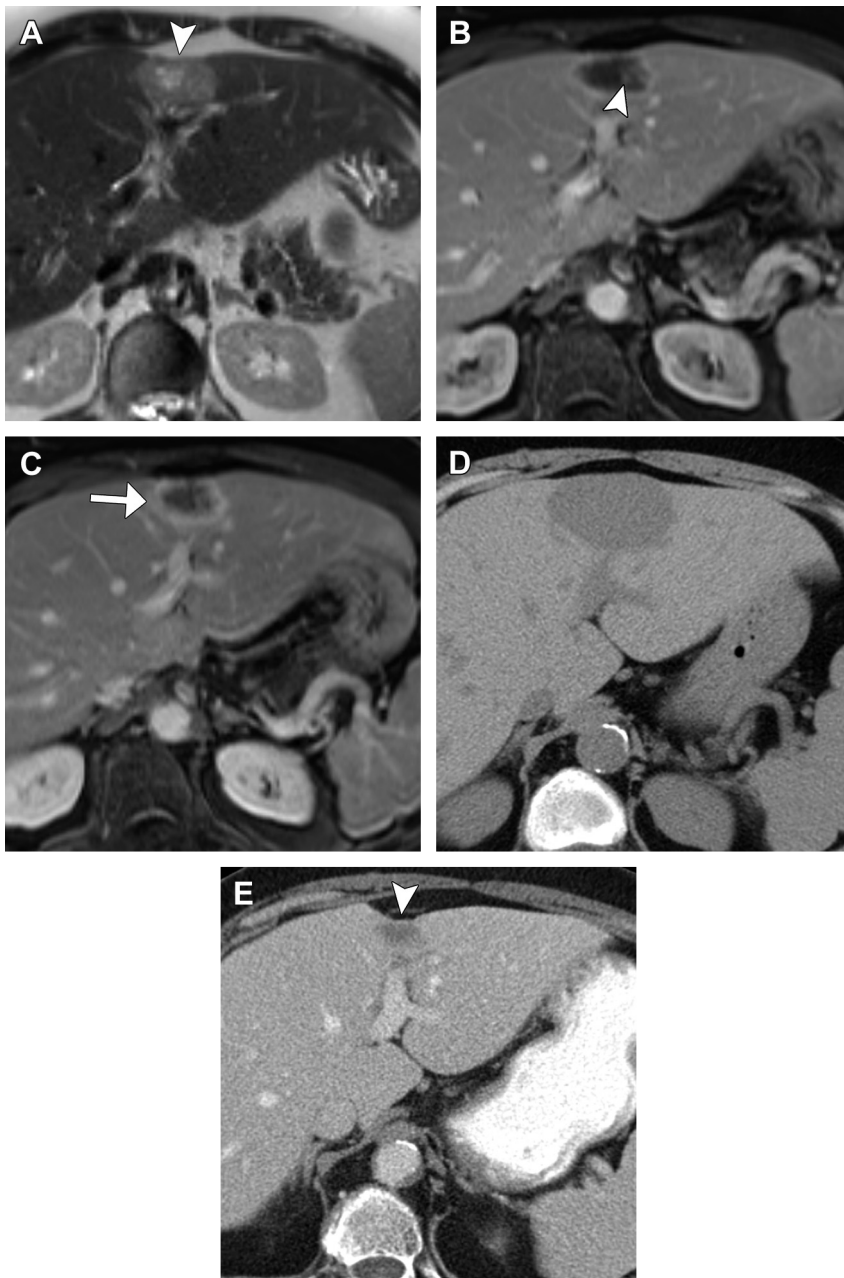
Sclerosing hemangioma (A) Heterogeneous, mildly T2 hyperintense mass with overlying capsular retraction (*arrowhead*). (B) Portal venous phase image demonstrates a continuous rim of enhancement with some internal nodular foci of enhancement (*arrowhead*). (C) Equilibrium phase image shows progressively thick rim of peripheral enhancement (*arrow*). Biopsy performed at this time was consistent with a hemangioma. (D) Noncontrast CT image from an outside institution 2 years prior shows that the mass was previously larger. (E) One year later, it continued to decrease in size with progressive capsular retraction (*arrowhead*).
